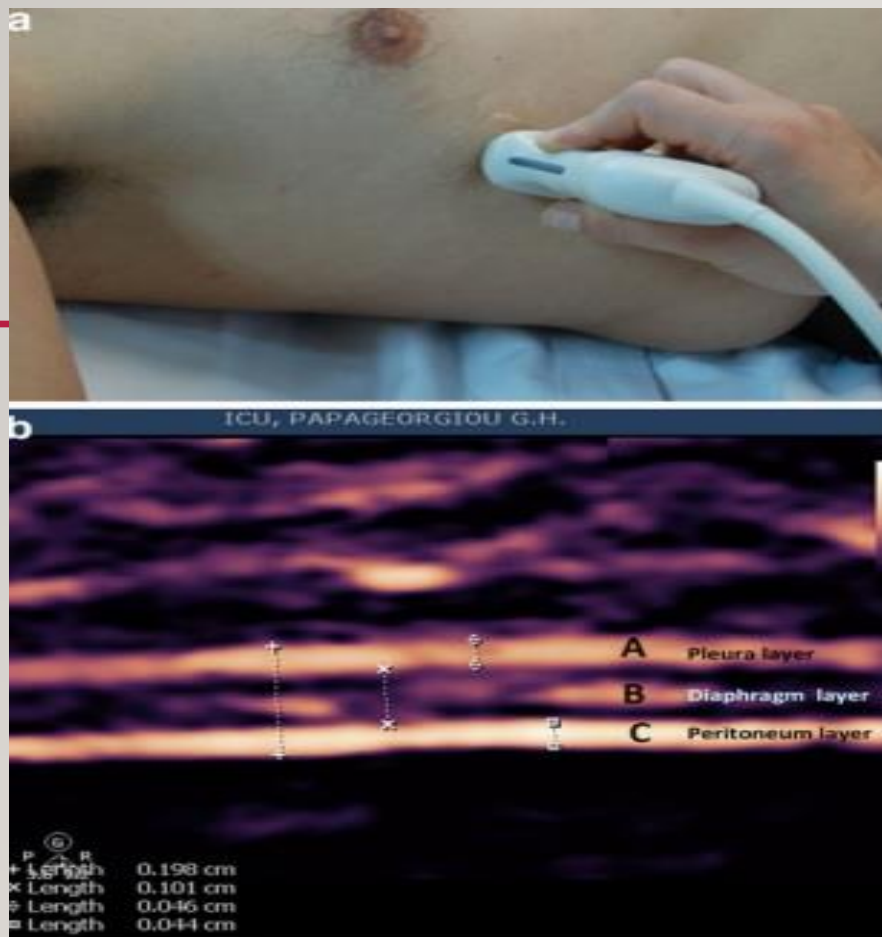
a Probe position for B and M mode diaphragmatic thickness measurements in the zone of apposition with 10–12 MHz probe. b B-mode sonography of the diaphragm in the zone of apposition. Echogenic diaphragmatic pleura, B non-echogenic central layer, echogenic peritoneal layer. Notice the thickness measurement of each layer
